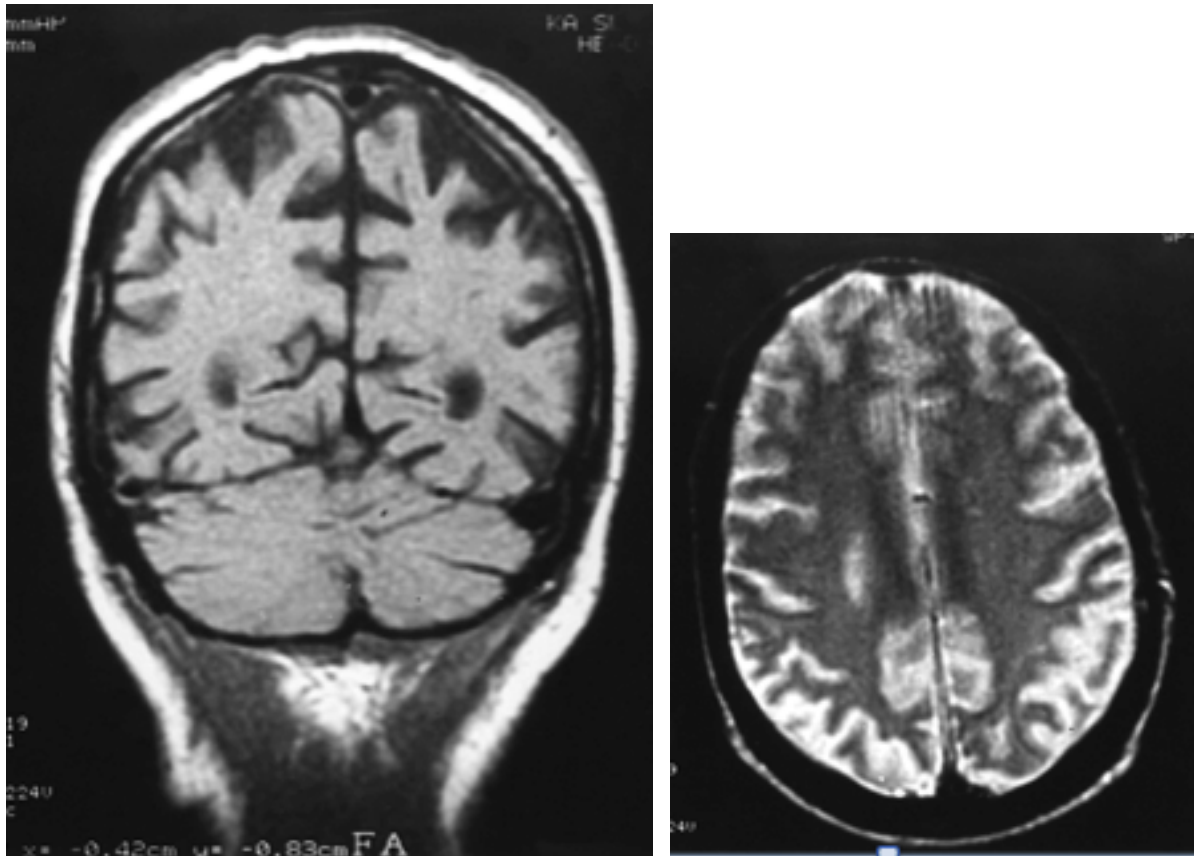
Brain MRI of a patient with troubles in performing manual tasks and an inability to write. Coronal T1 (left) and axial T2 (right) with gross posterior cortical atrophy especially of the left parietal and temporal lobes. (Ross et al., 1996)^[80]
